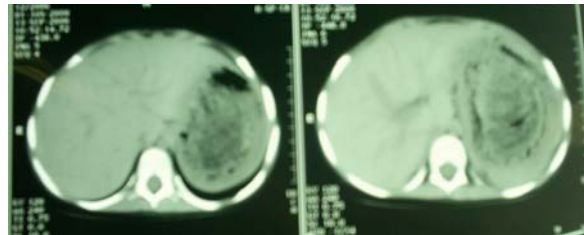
CT scan showing intragastric concentric mass of the 2nd patient.
